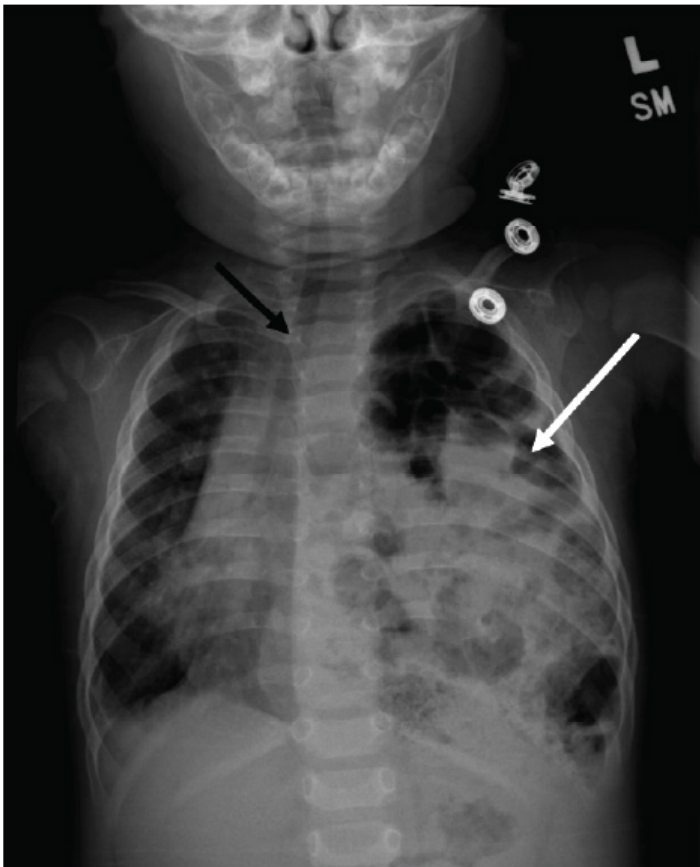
Chest radiograph with white arrow indicating an area of herniated bowel throughout the left hemithorax and black arrow indicating rightward tracheal deviation and mediastinal shift.
